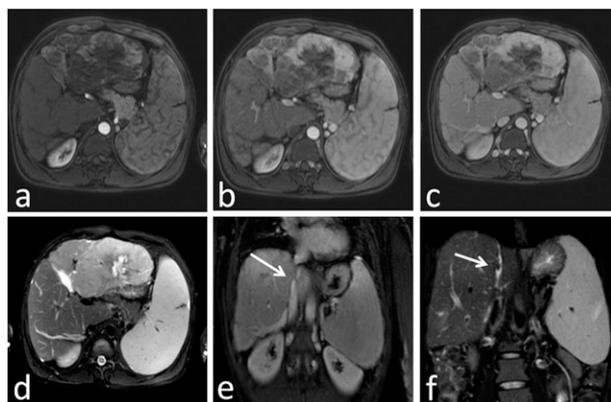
Multiphase magnetic resonance imaging of the abdomen shows a large mass lesion in segments III and IV, on the background of a cirrhotic liver. The mass shows progressive enhancement on (a) arterial, (b) portal, and (c) venous phases on contrast imaging. The stenotic intrahepatic and suprahepatic part of the inferior vena cava also can be visualized: arrows in (e) and (f).
